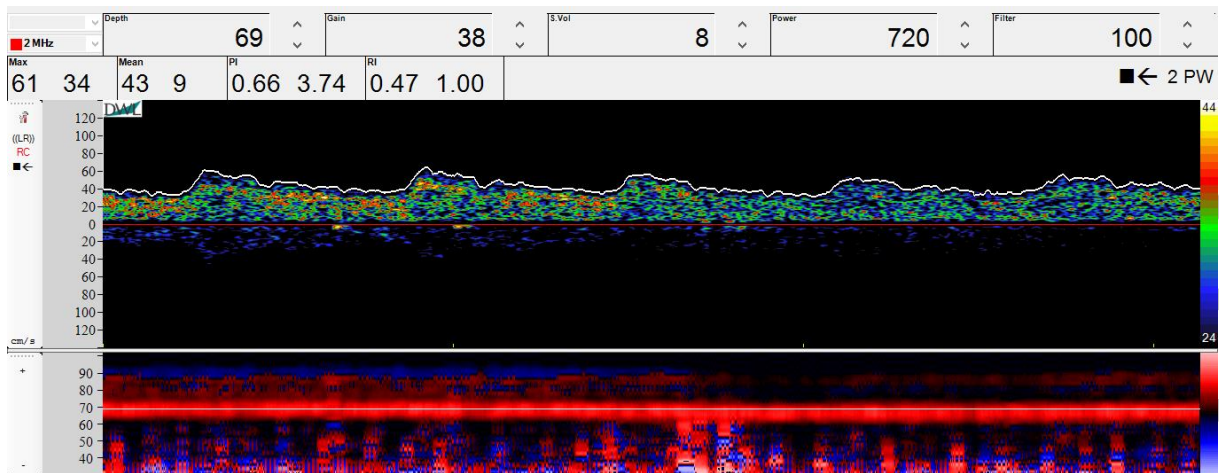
An example of transcranial doppler ultrasound in the target vessel before water pipe smoking (flow analysis in right MCA)
